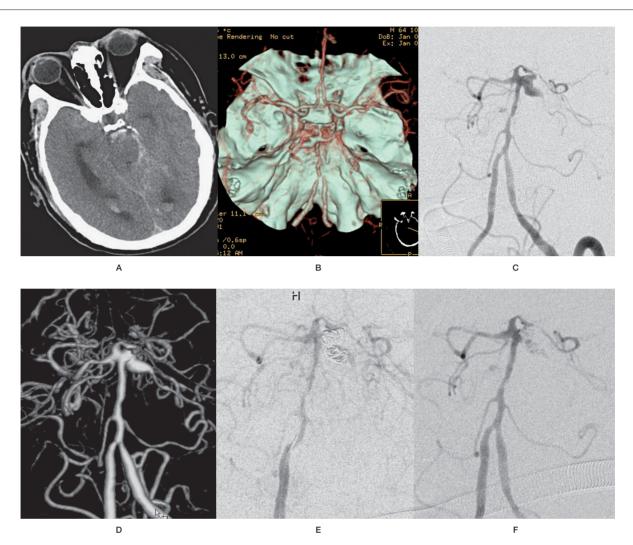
SCA fusiform aneurysm (Case 1).A) CT scan showing SAH and severe bleeding in areas around the interpeduncular cistern. B) CTA showing a fusiform aneurysm at the origin of left SCA and segmental basilar artery due to spasm. C,D) DSA and 3D-DSA of the aneurysm. E) DSA showing occlusion of the aneurysm and the parent artery and subtle neck remnant of the aneurysm. F) Angiographic follow-up examination showing the subtle neck remnant did not grow again.
